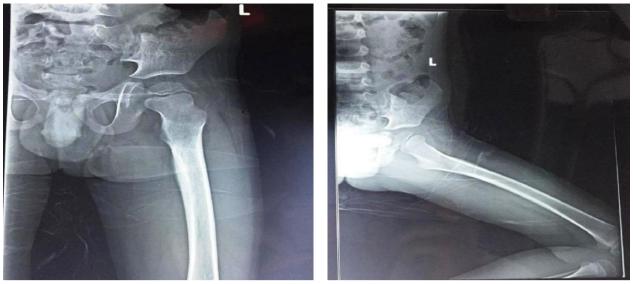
X-ray left femur showing solid periosteal reaction with cortical thickening.
